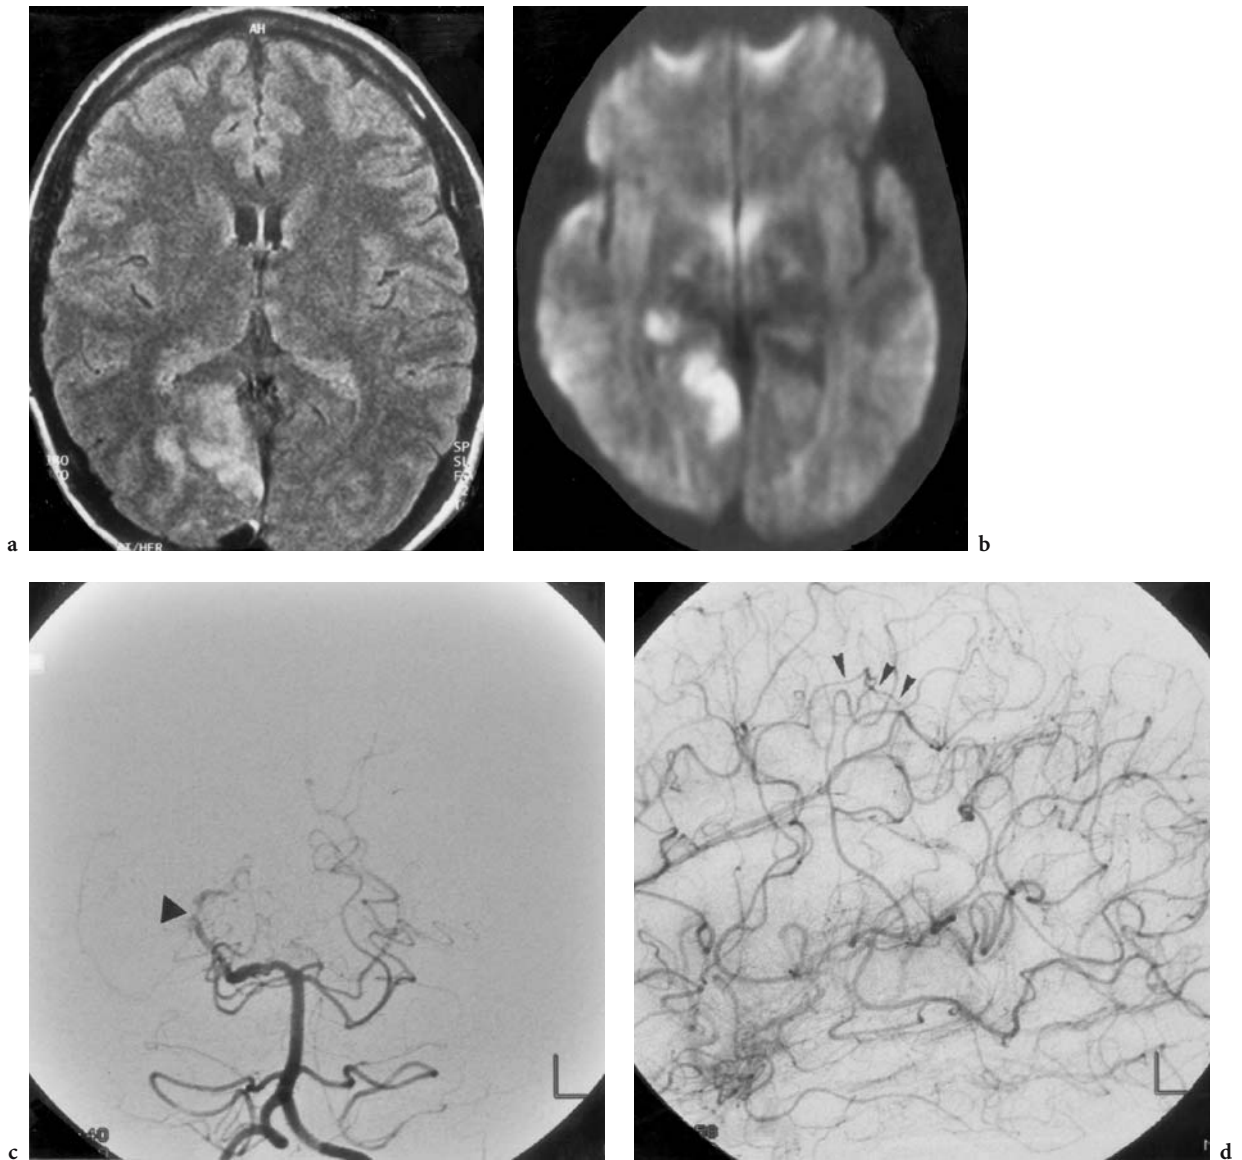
A 33-year-old woman with acute homonymous hemianopia to the left. Diagnosis: infarction of PCA associated with cerebral vasculitis. MRI: a Axial T2-weighted FLAIR image with an area of high signal intensity in the calcarine region. b Corresponding DW image with corresponding and additional signal enhancement in the right parahippocampal gyrus. Intra-arterial DSA: c Early arterial phase in AP (Town) view of the left VA with clearly apparent irregularity with narrowing (*arrowhead*) and fusiform widening of the right PCA in the entire distribution area. d Arterial phase of the left ICA in lateral view, confirming the diagnosis by segmental irregularity (*arrowheads*) of the distal branches of the MCA
